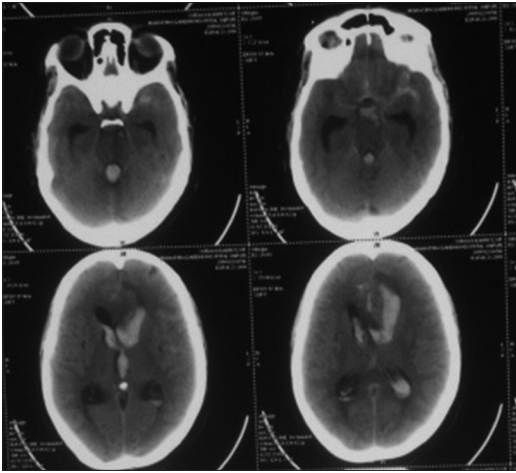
Plane computed tomography scan of brain showing subarachnoid hemorrhage in bilateral sylvian fissure, interhemispheric fissure with intraventricular extension without any evidence of infarct
